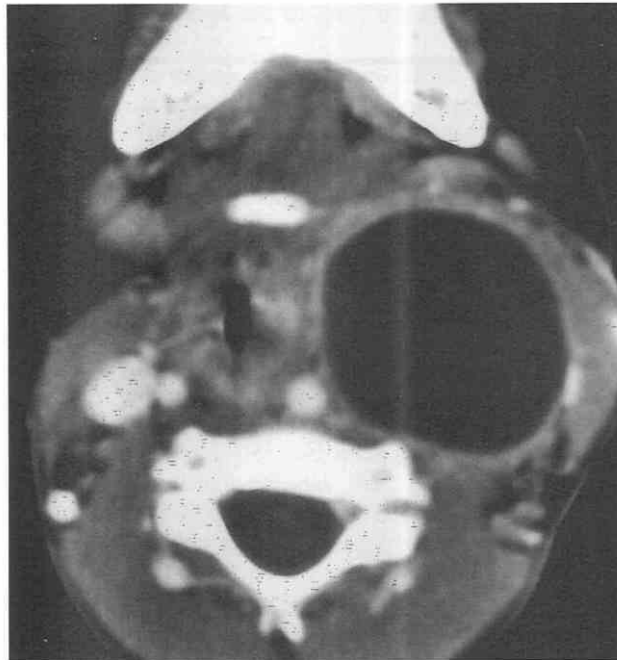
Thymic cyst. Axial postcontrast CT scan. A large, round, nonenhancing mass is present in a position similar to a second branchial apparatus cyst; however, the sternocleidomastoid muscle lies in a more lateral position.
